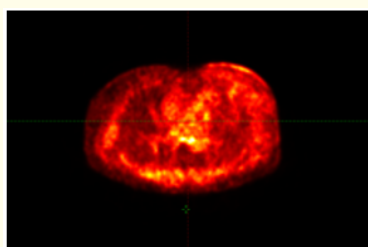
PET CT done after chemotherapy with eribulin.
